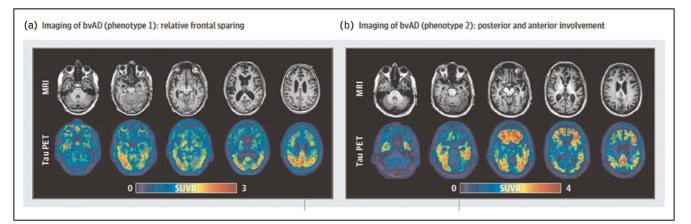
Neuroimaging features (Structural MRI on the top, tau-PET on the bottom) observed in the subvariants of behavioral variant of Alzheimer's disease (bvAD): (A) relative frontal sparing subvariant; (B) Posterior and anterior involvement subvariant. Reproduction from [4^{••}].
